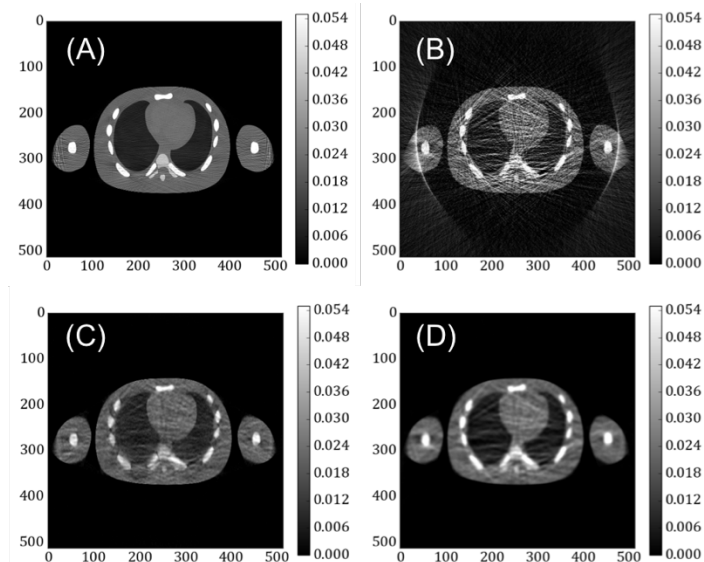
Comparison of reconstructed 10 mAs NCAT CT images
